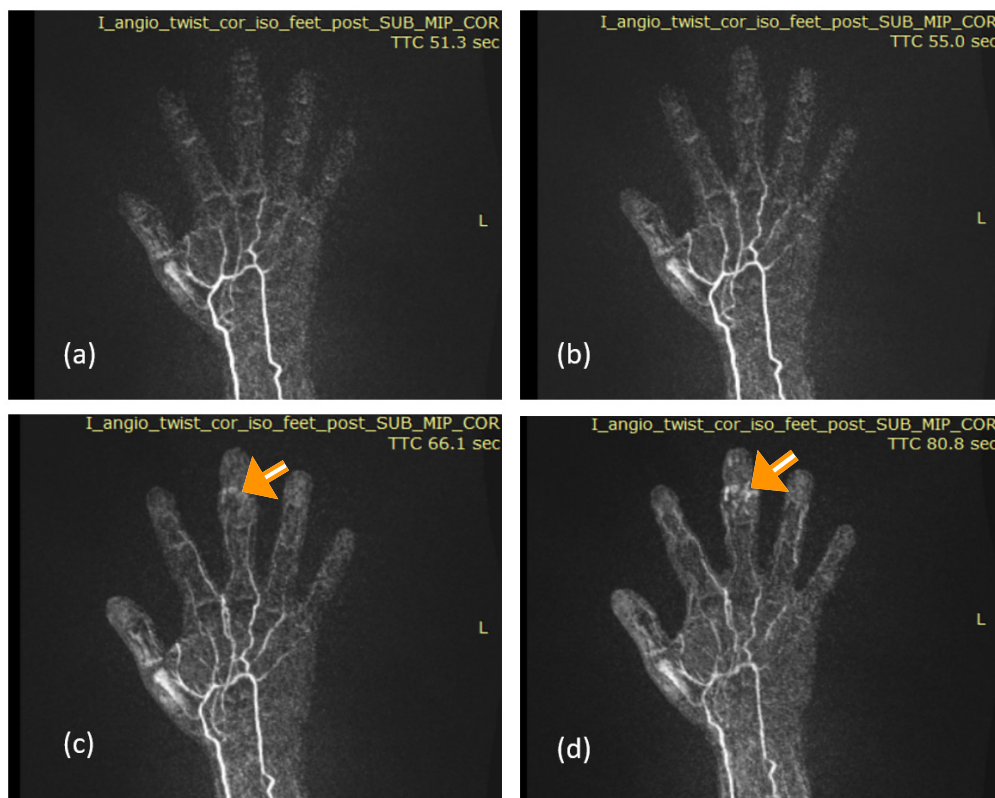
(a-d) Dynamic contrast MRI TWIST sequence: the lesion shows no arterial or early venous phase enhancement. Progressive enhancement noted in the late venous phases. (c, d). No evidence of the dilated arterial feeders or draining veins.
